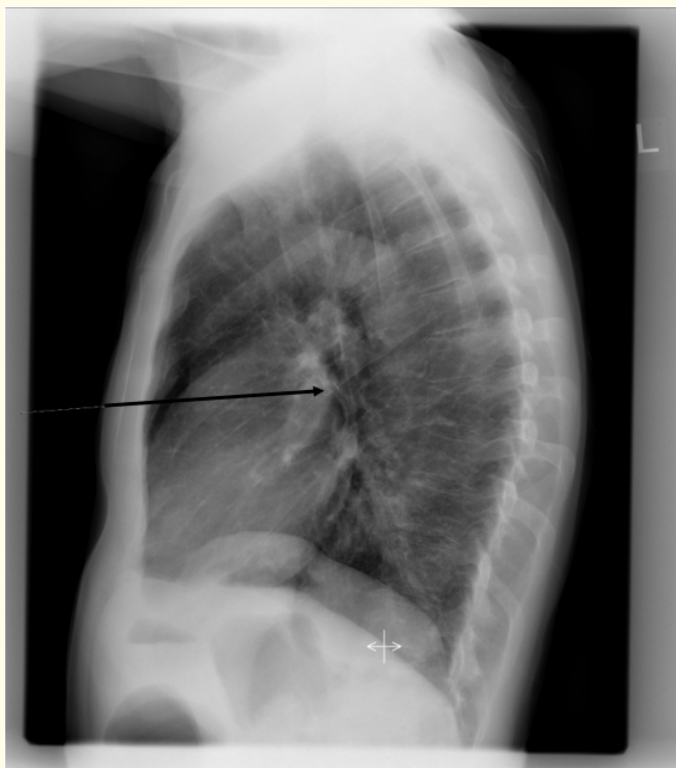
Lateral thorax X-ray.
